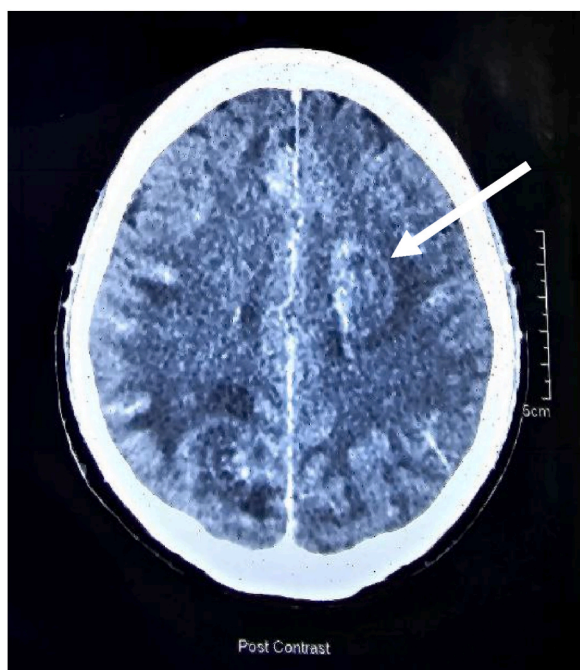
Head CT scan of the patient show a ring enhancement lesion.
